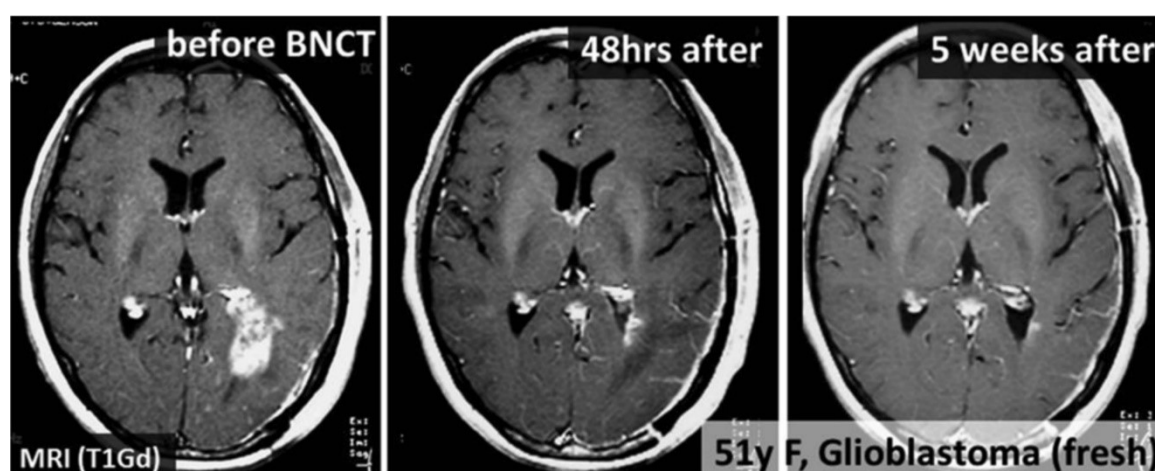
MRI images of the follow-up of a patient with glioblastoma treated with BNCT [Bart12].
